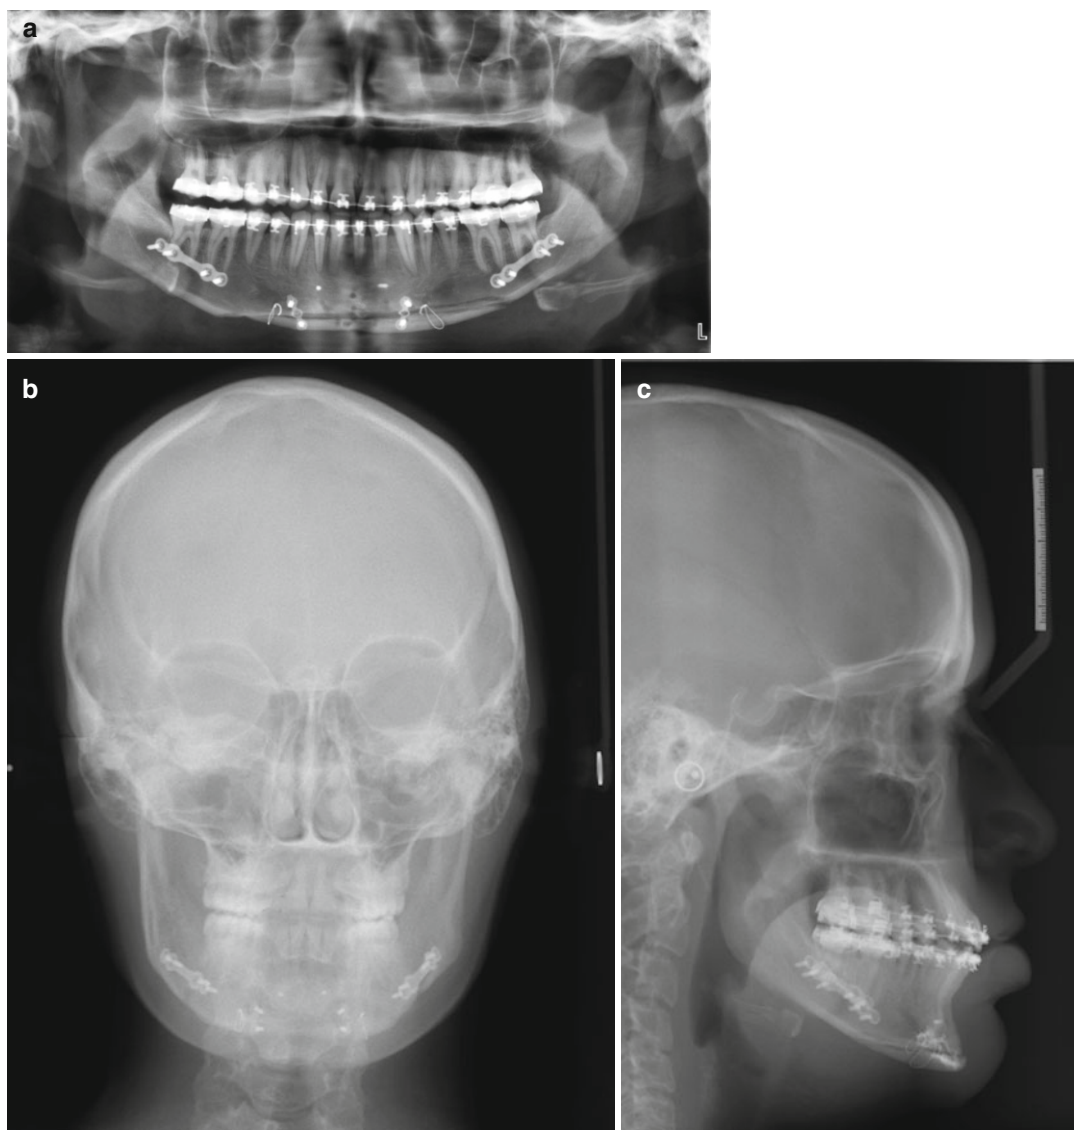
Postoperative (a) panoramic radiograph, (b) AP, and (c) lateral cephalograms confirm correction of the asymmetry with leveling of the occlusal plane.
